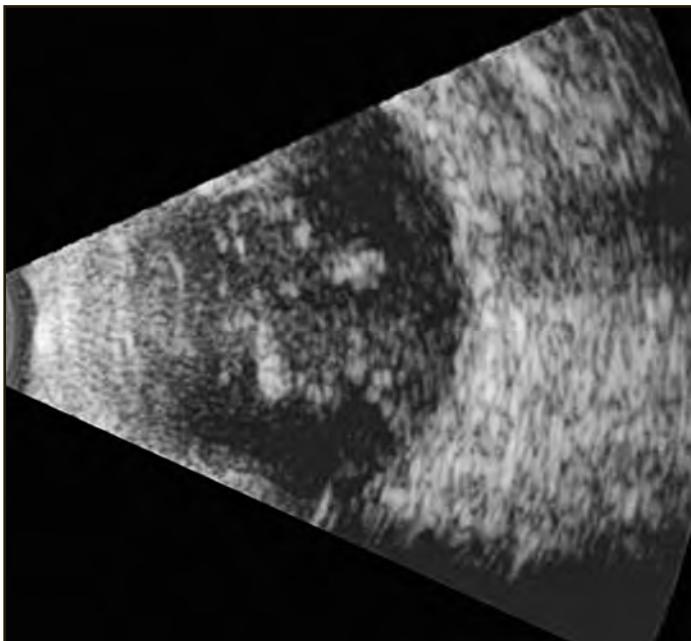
B-Scan of a Vitreous Haemorrhage. The vitreous is detached peripherally but adherent to the retina posteriorly probably due to proliferations. The hyper-reflectivity is due to vitreous hemorrhage, probably with some proliferations since it is still adherent to the retina. It is important to perform B mode ultrasonography to rule out retinal detachment or unsuspected choroidal tumors.
